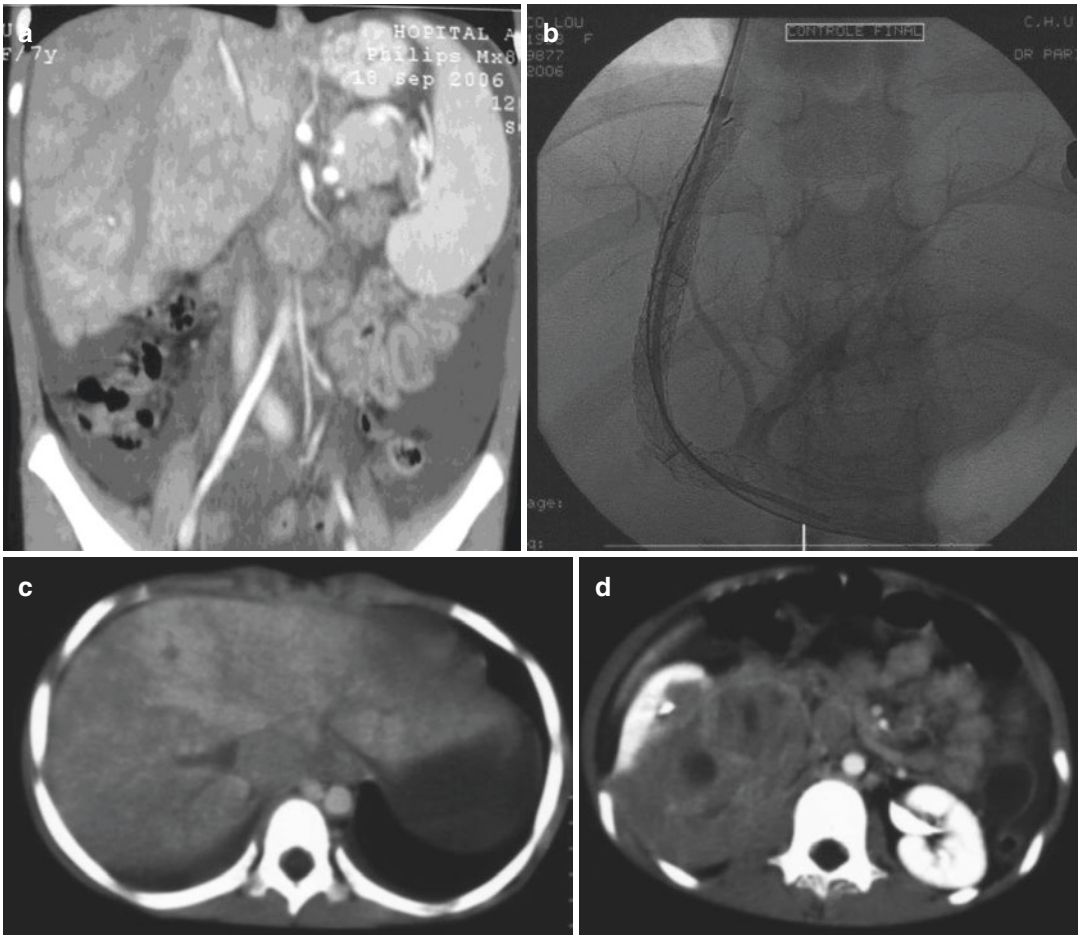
Budd-Chiari syndrome. Ten-year-old girl presenting with abdominal pain and rapid abdominal enlargement (a, b). (a) CE-CT at the venous phase shows the heterogeneous enhancement of the liver with absence of opacification of the enlarged right hepatic vein that is thrombosed. Note the presence of ascites. (b) after failure of medical treatment and hepatic vein angioplasty, placement of a TIPSS allowed the resolution of portal hypertension. Essential thrombocythemia was found as a
